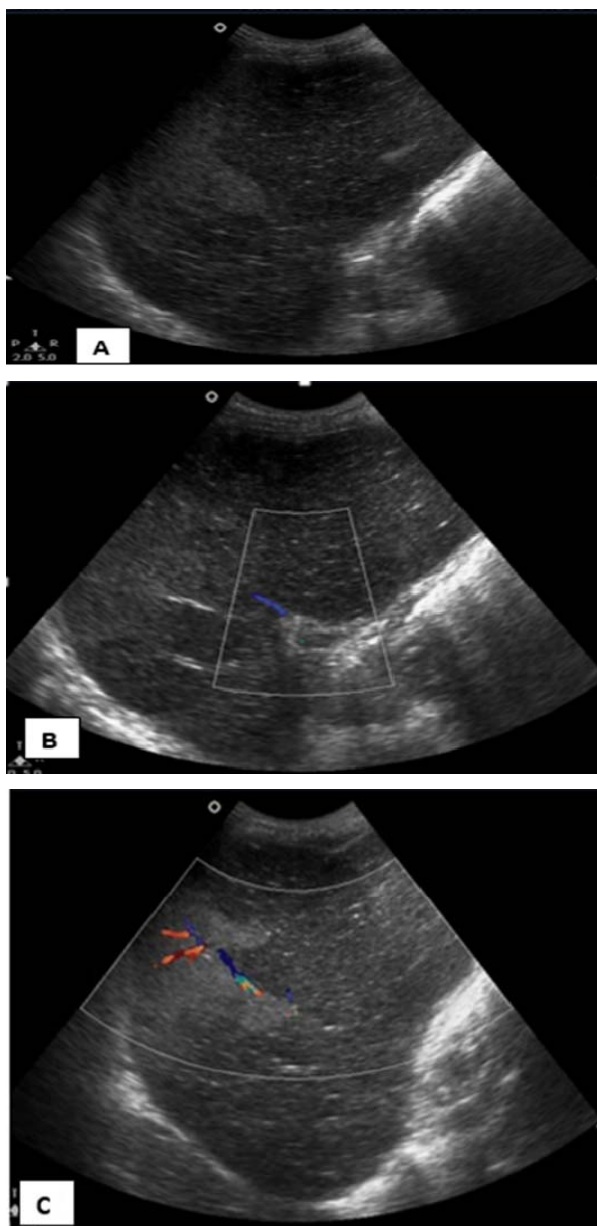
transabdominal ultrasound of a patient with acute abdomen showing heterogeneous predominantly hypoechoic spleen in the mid abdomen (a) with no parenchymal flow on color Doppler interrogation (b & c).
